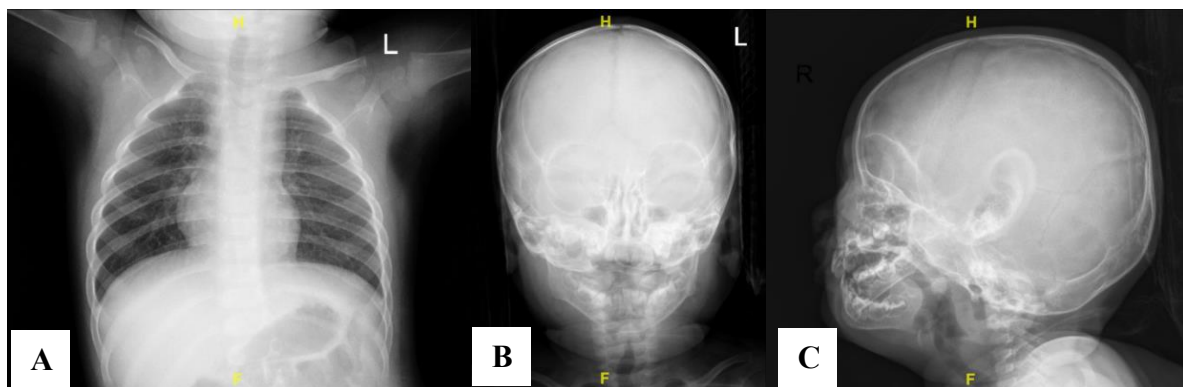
Patient's x-ray: A. Chest x-ray, B, C. Skull AP and lateral x-rays.
